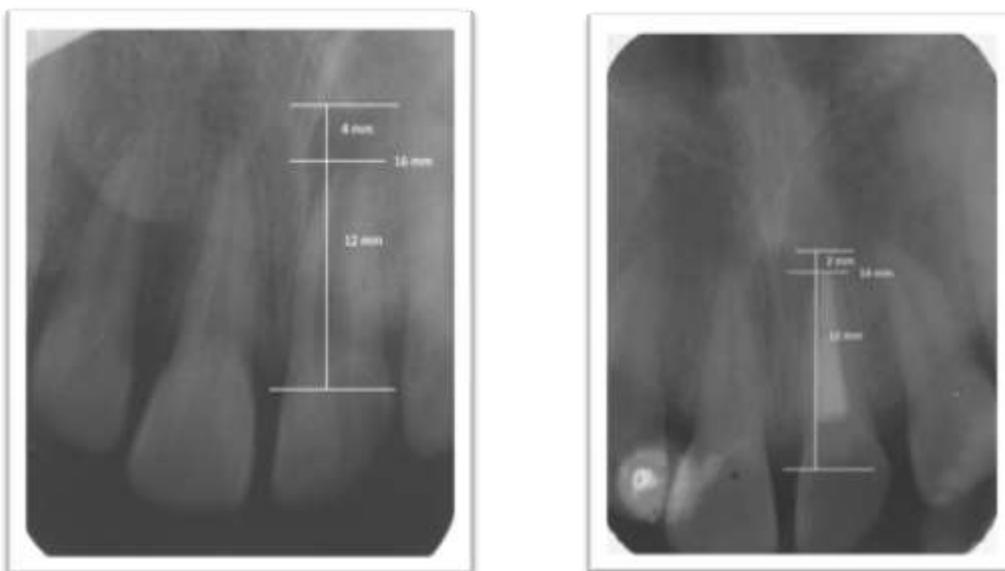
For the measurement of periapical lesion , distance from cementoenamel junction (CEJ) to root end, CEJ to outer border of lesion and root end to the outer border of lesion was considered for both preoperative and postoperative radiographs.
